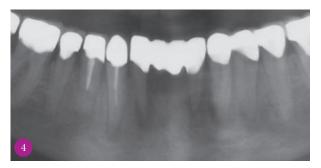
Section of the orthopantomogram showing areas of obvious periapical rarefaction.
